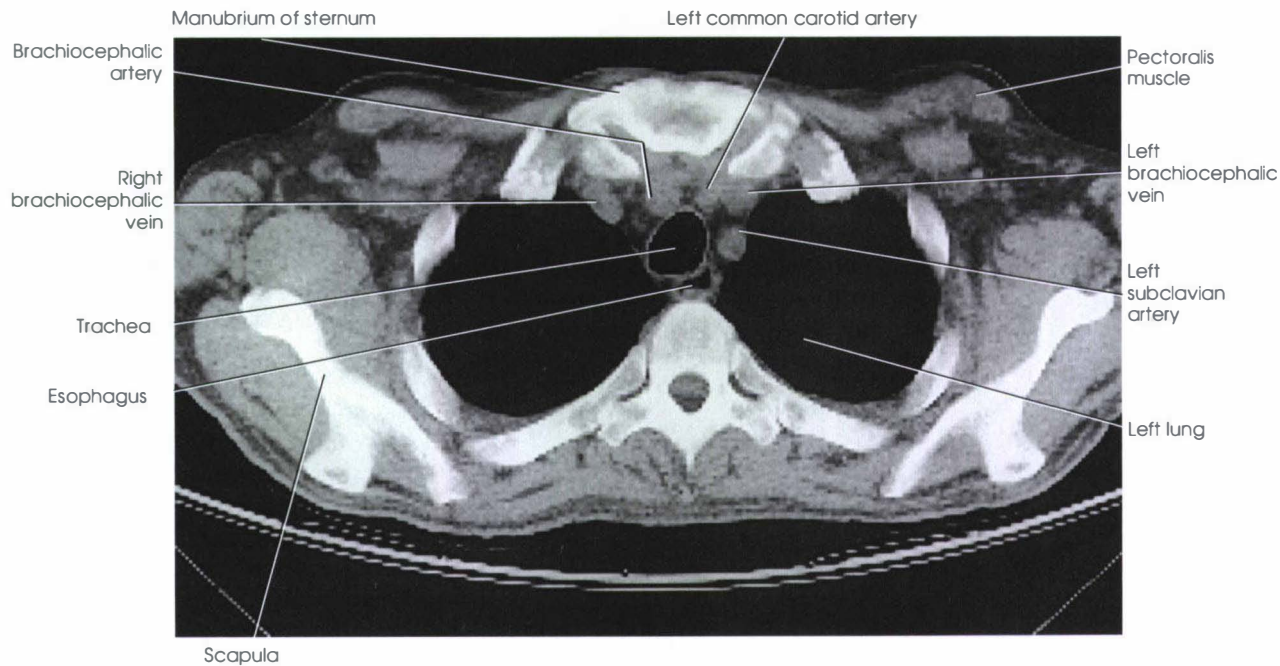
CT image corresponding to Fig. 27-19.
